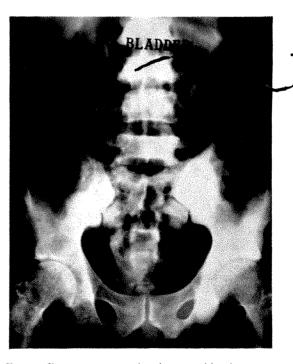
Roentgenogram showing osteoblastic metastases from carcinoma of bladder. No primary prostatic cancer.
